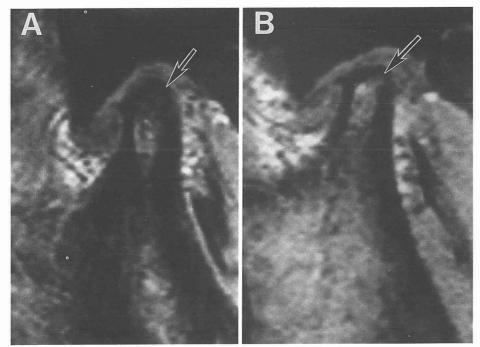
A, Right TMJ on mouth closing. B, Left TMJ on mouth closing. Six months after the first examination, sagittal T1-weighted MR images (FE 30/13, $\theta=30^{\circ}$) revealed improvement of the low signal intensity in the bilateral mandibular condyles (black arrow). Anterior disc displacement on mouth closing and morphological change were not seen.
